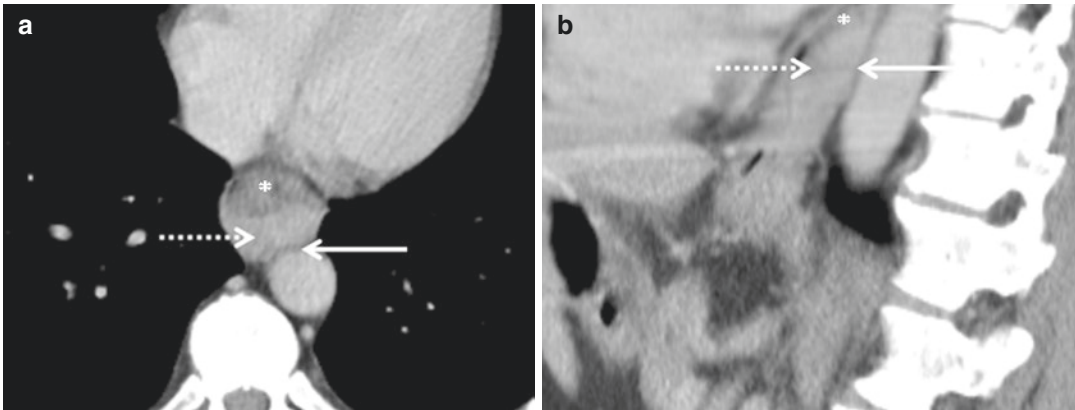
(a) Axial and (b) sagittal CT image of a pT2N0 tumor. The polypoidal tumor mass (*dashed arrows*) arises from the posterior wall of the esophagus. The outer margin of the wall is smooth with no evidence of extension
